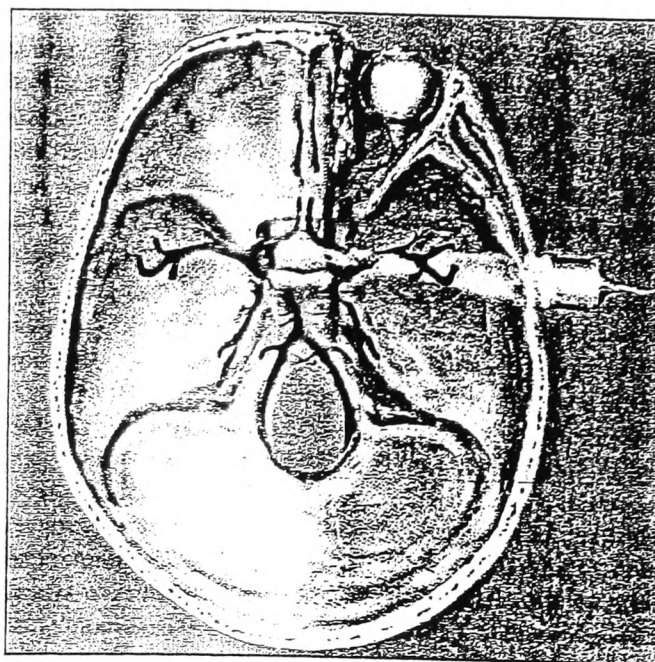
Coupe de la boîte crânienne au doppler transcranien.
